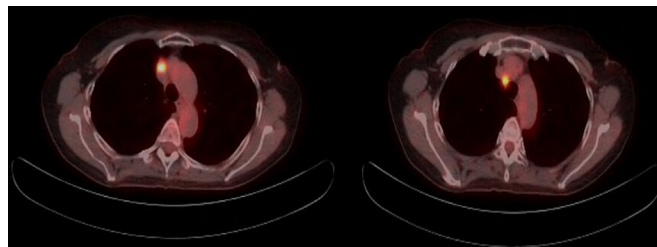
PET/CT scan findings include a hypermetabolic right level four cervical lymph node, measuring 6 mm (SUV 3.2), and right paratracheal lymph nodes (SUV 5.2), measuring 8 and 9 mm, respectively. PET/CT, positron emission tomography/CT. Standard uptake value (SUV) is a semiquantitative method of determining metabolic activity in a region of interest in PET/CT scan.
